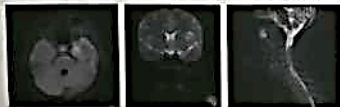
The brain MRI revealed anterior horns with an increased signal in T2 images after gadolinium contrast at cortical and subcortical (lesion region) area of the optic chiasm. The medullar MRI also showed multiple areas with a contrast enhanced longitudinal T2 signal that included the medullary cone, the largest encompassing 2 segments.
